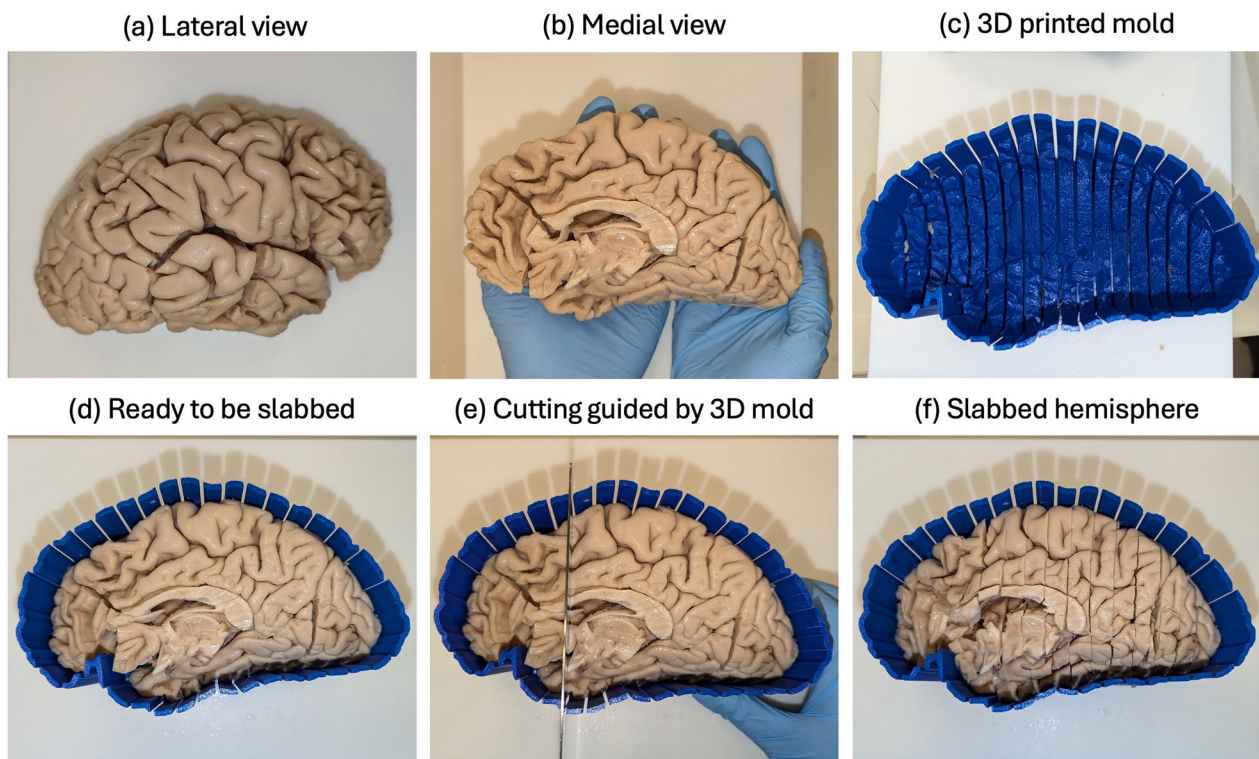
Custom 3D printed mold-guided slabbing of brain hemisphere. Postmortem whole hemisphere brain tissue of a donor, deceased at age 69 years, with a diagnosis of Pick's disease - a type of frontotemporal dementia. a Lateral view of the hemisphere. b Medial view of the hemisphere. c Custom, subject-specific 3D printed mold created using a segmentation of the MRI scan. d Hemisphere fits seamlessly inside the mold and is ready to be slabbed. e The notches in the mold guide the knife to ensure uniformly parallel and equidistant cuts of the tissue. f Hemisphere inside the mold after the slabbing is complete
